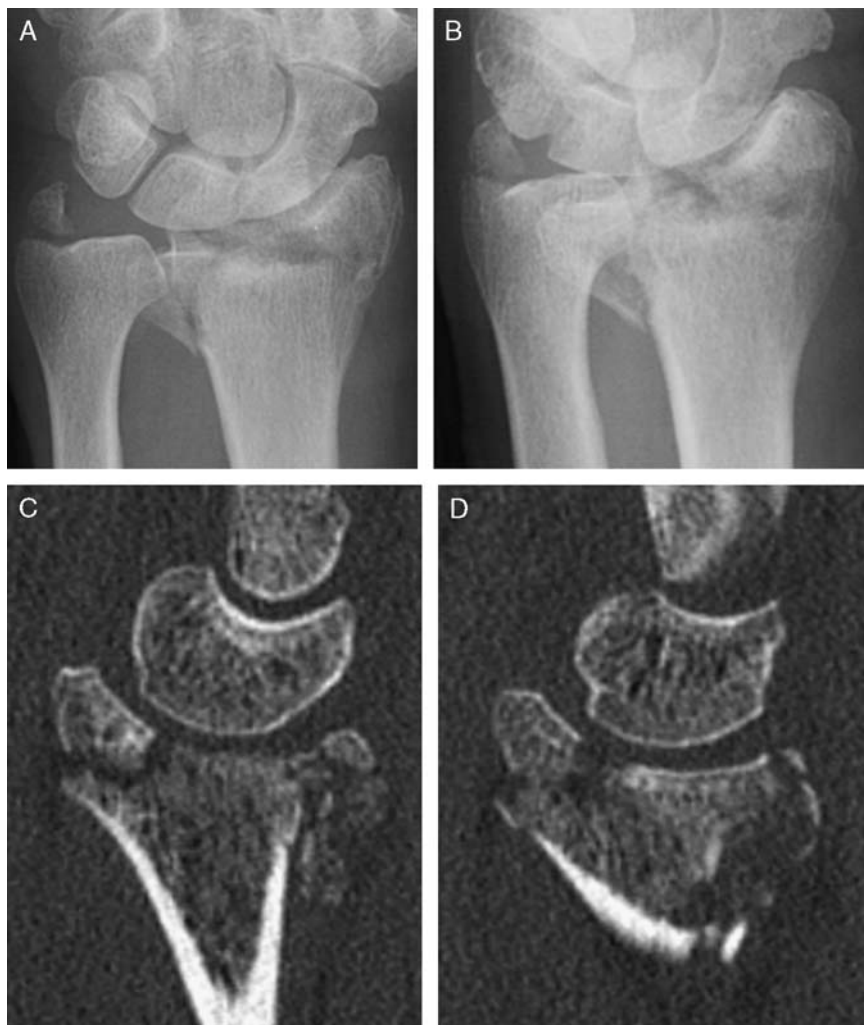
A, Posteroanterior x-ray of a 67-year-old man with comminuted AO type 3 left distal radius fracture, including a distal volar lunate facet/volar rim fragment B, Oblique x-ray showing intra-articular displacement and comminution. C, Sagittal computed tomography (CT) scan image with volar to the left, demonstrating the small distal volar lunate facet/volar rim fragment, loss of volar inclination, and dorsal comminution to the right of the image. D, Sagittal CT scan image further demonstrating the small distal volar lunate facet/volar rim fragment.
